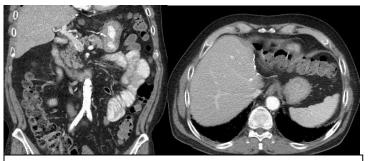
CT* scan of the abdomen follow up. Patient's transverse and coronal images 24 months post-surgery with no signs of disease recurrence.
